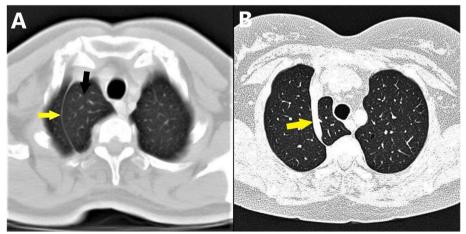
a, b HRCT thorax of normal azygos lobe and fissure. a Axial HRCT thorax image demonstrates the azygos fissure as a C-shaped thin curvilinear density (yellow arrow) and the azygos lobe (black arrow) medial to it (courtesy of Dr. Ramesh Giti, MD, Mashhad University of Medical Sciences, Mashhad, Iran). b Axial HRCT thorax shows the azygos vein as a thicker band (yellow arrow) within the right upper lobe
